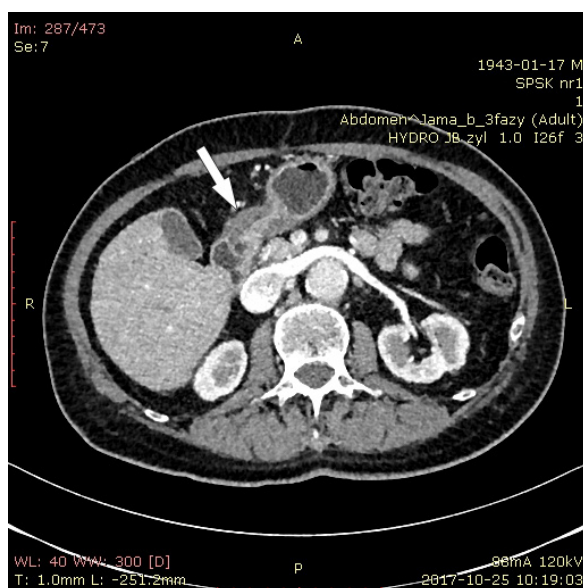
The hydro-CT image in the axial projection shows the cancer of the pyloric antrum of the stomach affecting the muscle layer (lower density) (arrow)
